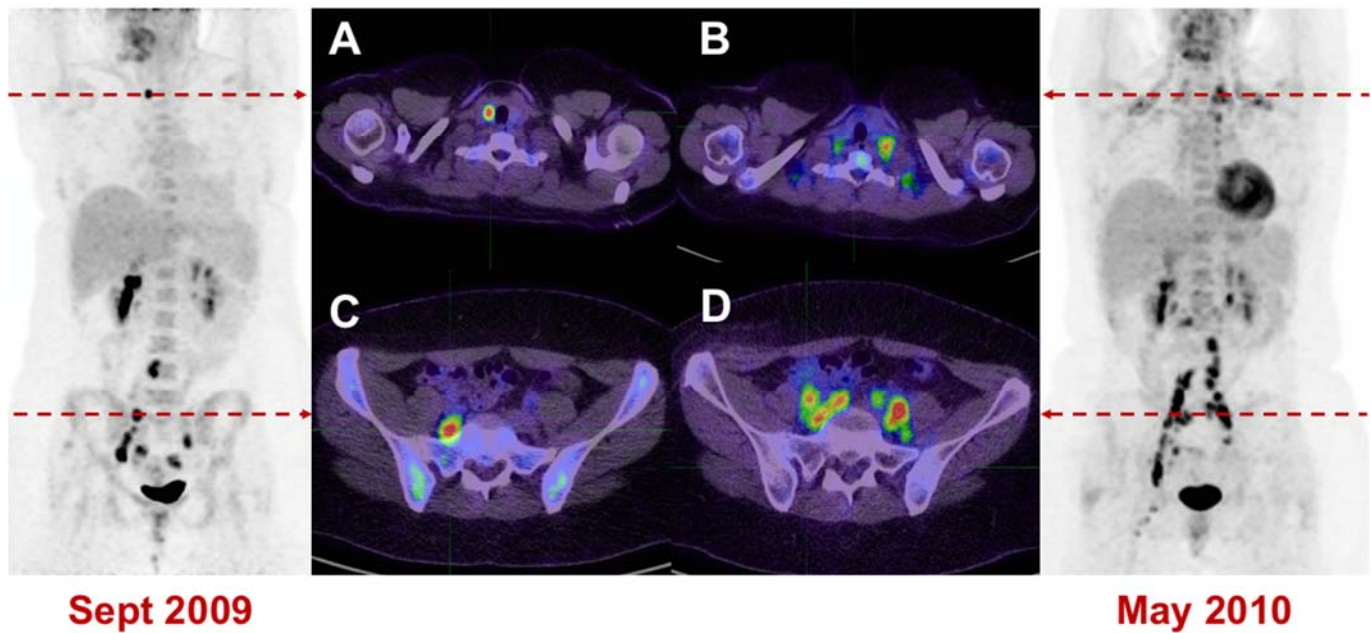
Intensely FDG-avid TI (SUVmax 16) was identified on a staging FDG PET/CT scan of a 28-year-old woman with Stage IIIB poorly differentiated cervical carcinoma & persistent FDG-avid pelvic nodal disease. Ultrasound-guided cytologic evaluation demonstrated papillary thyroid carcinoma treated with total thyroidectomy (5mm PTC with no adverse features). Upper images demonstrate (A) baseline FDG-avid thyroid nodule & (B) subsequent cervical carcinoma metastases to supraclavicular nodes. Lower images demonstrate (C) baseline FDG-avid pelvic lymphadenopathy with (D) subsequent disease progression. She passed away 10 months after the baseline PET/CT scan from progression of metastatic poorly differentiated cervical carcinoma.
